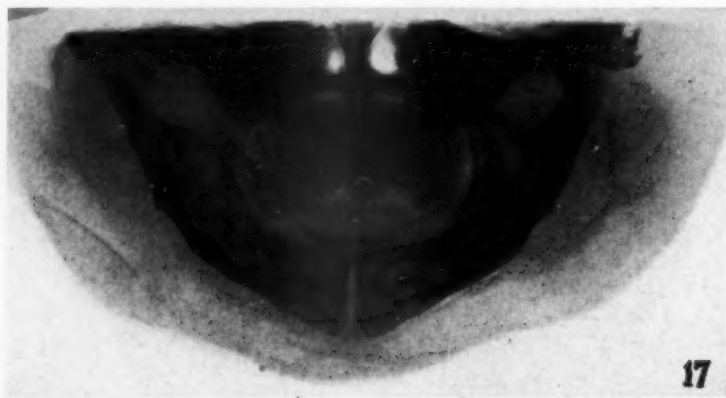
Roentgenogram showing the follicles of the deciduous teeth and first permanent molars in their usual position.
